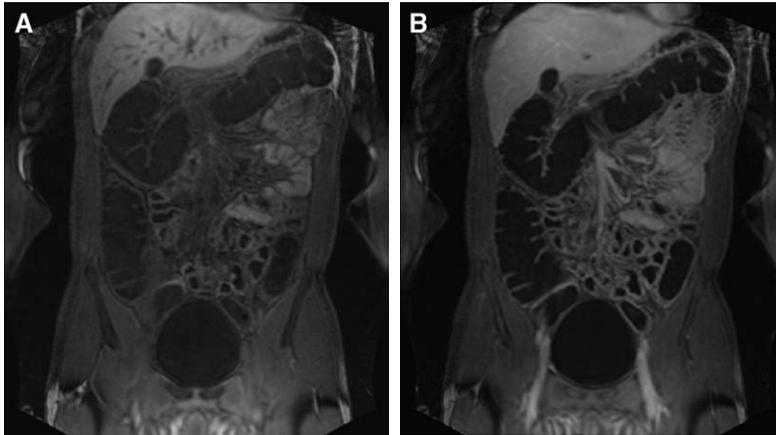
Pre- (*A*) and postcontrast (*B*) T1-weighted sequence. The colonic lumen is rendered dark because of the water enema. An avid contrast enhancement leads to a high signal of the colonic wall on the postcontrast scan.
